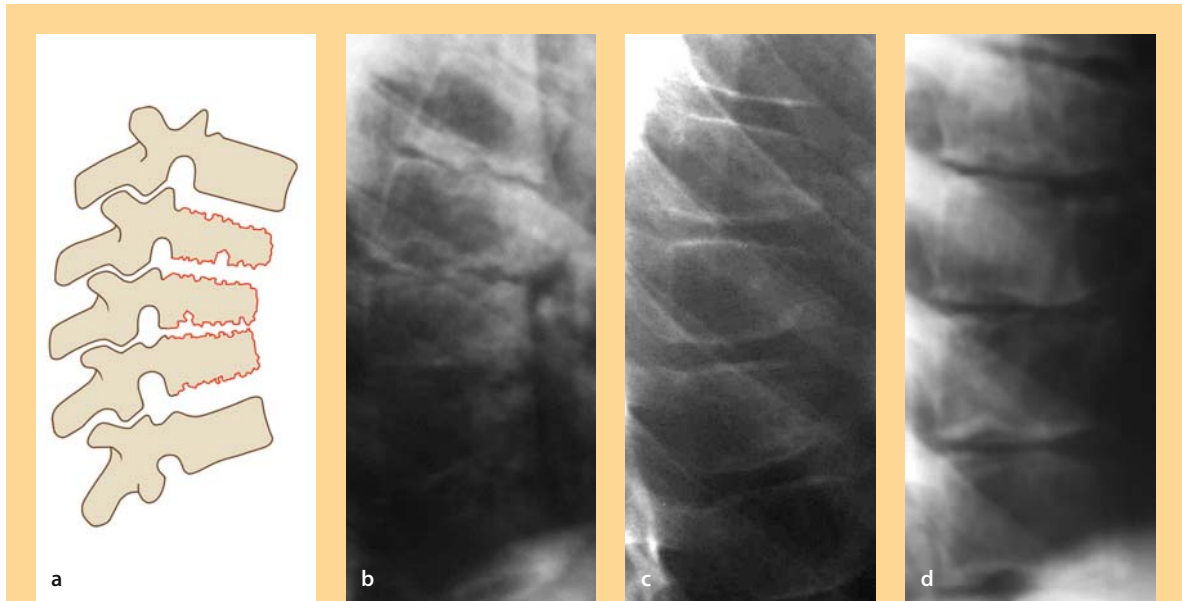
Typical radiographic features (Type I)
